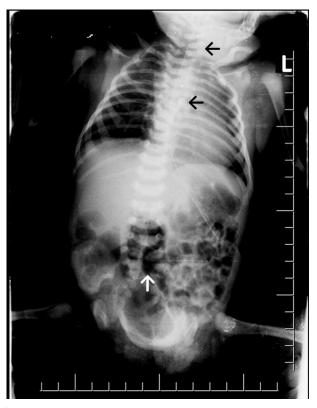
Vertebral radiographs showed: vertebral dysplasias (black arrows) and bifid L5 and sacrum (white arrow) are seen.
